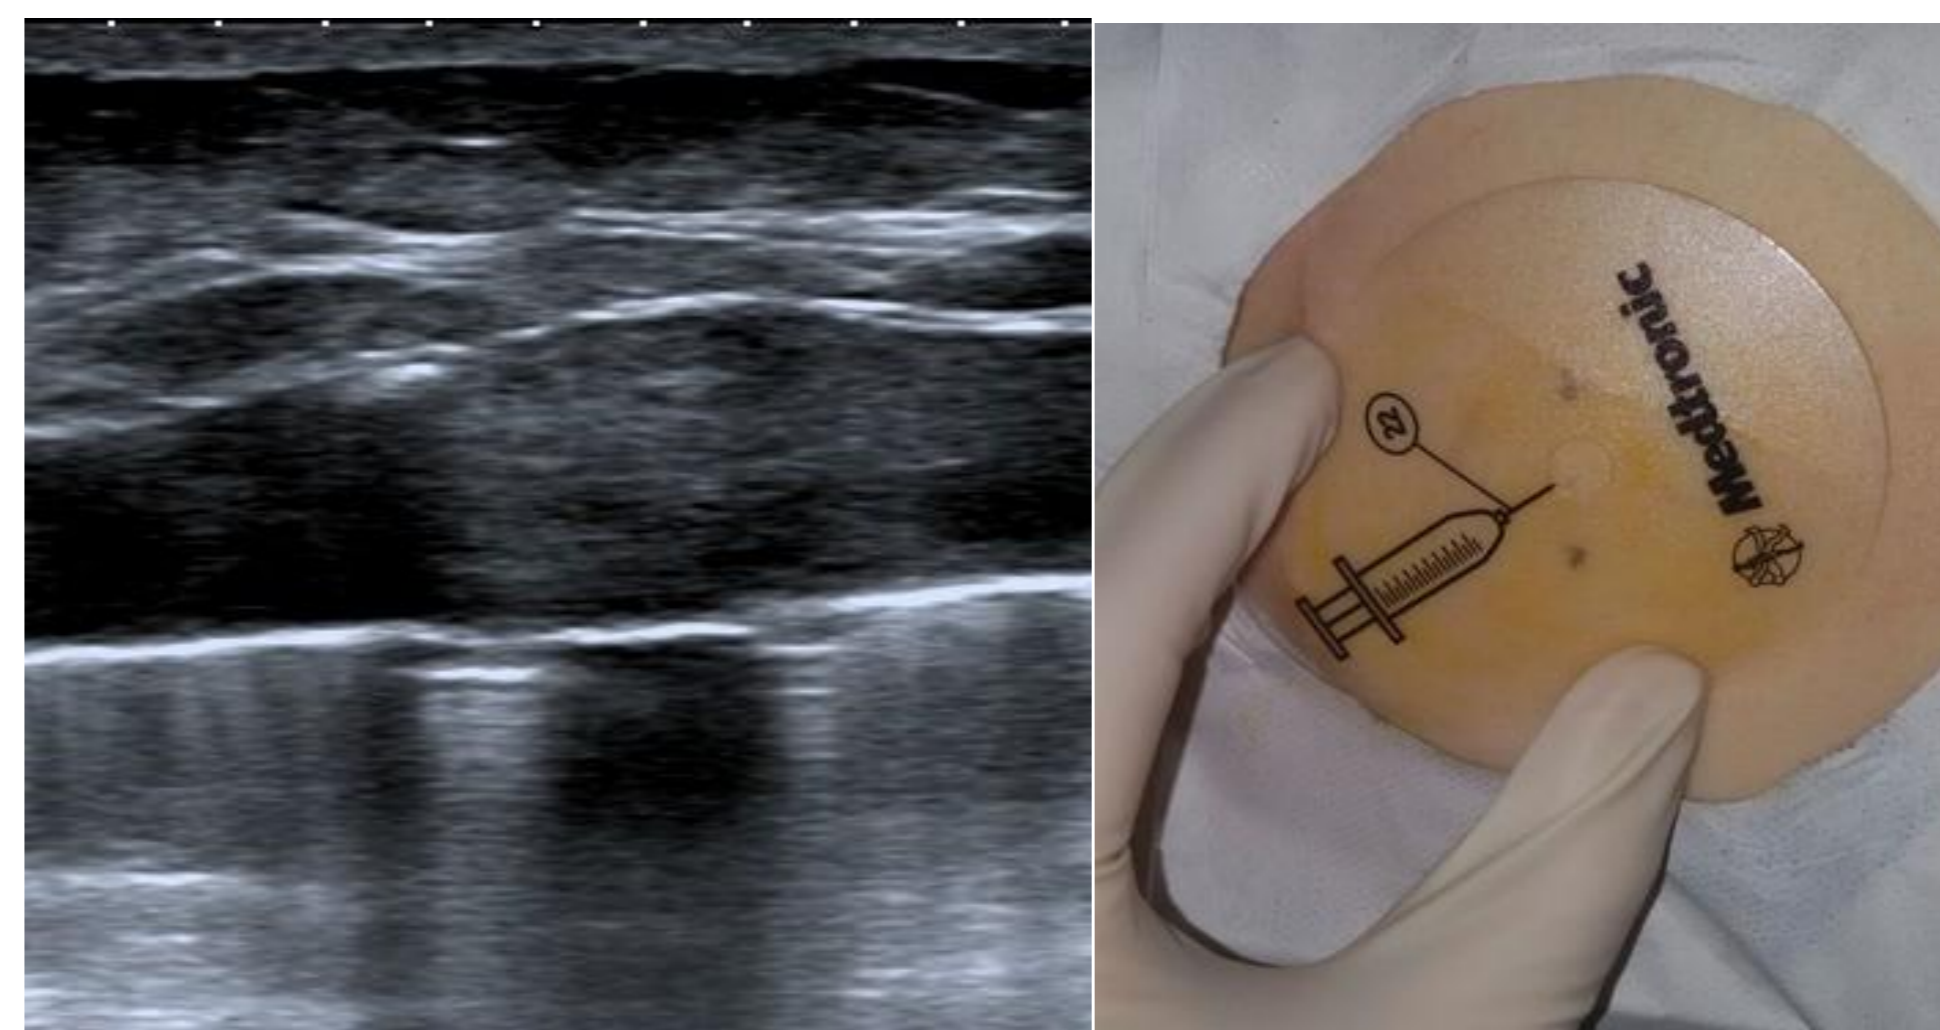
US imaging of ITB, surface of the intrathecal pump identified by a well-defined hyperechoic line with acoustic shadowing deep to this line with the shadows of the hole with the membrane. The distance between the skin and the pump was of less than 1cm; Photo pf Belly: Access port of the pump showed with the guidance of the refill template, black spots (marked on the bilateral side of the ultrasonic probe) identified with US completely match with the access of the pump.
